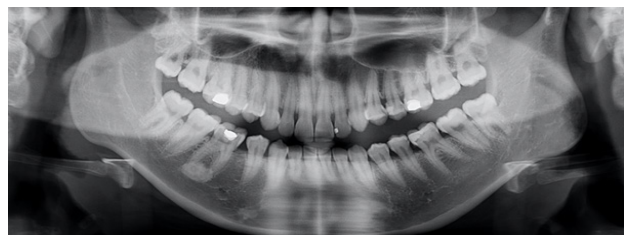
Case 1: Pre-treatment DPT prior to starting orthodontic treatment. Radiopacity present at periapical area of LR6 and beneath LR3
